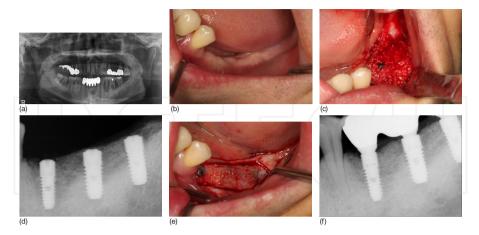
Guided bone regeneration using AutoBT powder (Kim Y.K., et al. Guided bone regeneration using autogenous teeth: case reports. J. Korean Assoc. Oral Maxillofac. Surg., 2011.) a): Initial panoramic radiography of a 44-year-old male patient. b): Preoperative intraoral view. Teeth were extracted 2 months ago. c): Implants were placed, and dehiscence defects were covered with autogenous tooth bone graft material. d): Periapical radiography 6 months after implant placement. e): Secondary surgery was performed, and flap was elevated. Excellent bone healing was observed. f): Periapical radiography 6 months after the final prosthetic delivery.
